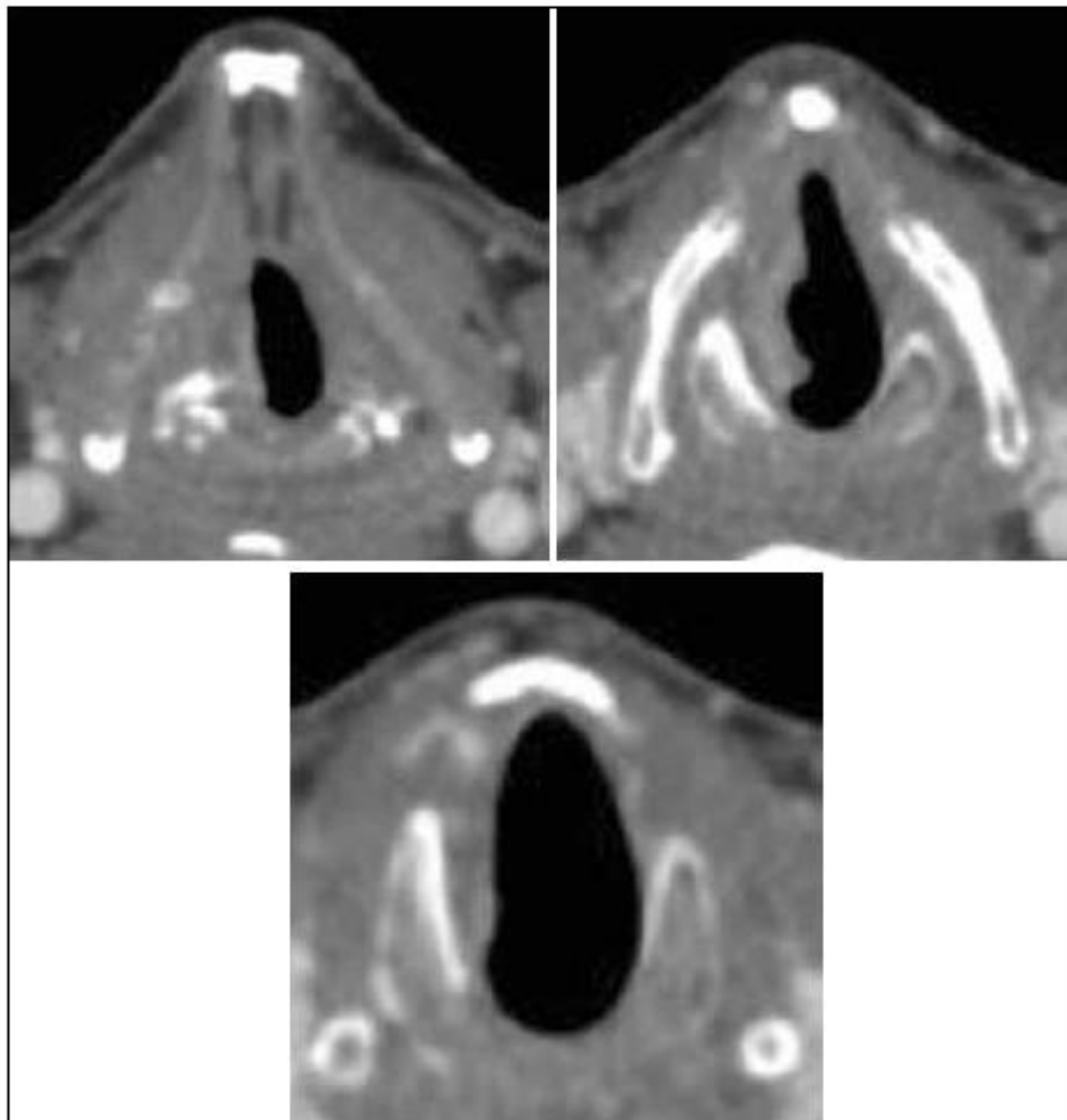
a-b) CT scan in axial view of right recurrent glottic T2 with impaired mobility of the vocal cord, extending superficially to the subglottic site along the elastic cone toward the cricoid cartilage. c) The tumour reaches the cricoid plate and ring.
